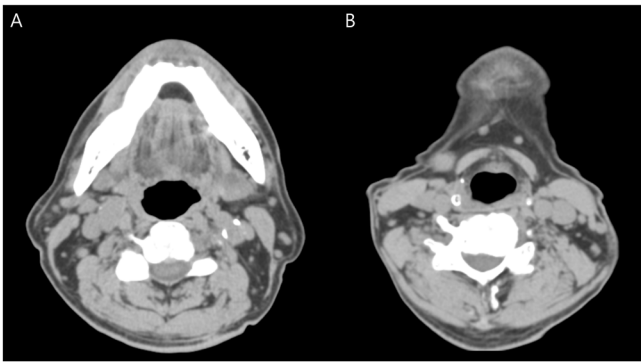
Pre-operative enhanced CT scan. (A) The scan reveals the complexity of distinguishing between a ranula and a lipoma based solely on Hounsfield units, a measure of radiodensity. The Hounsfield units for a ranula typically register around 100, while a lipoma ranges between 65 and 120. This overlap in values makes differentiation challenging. Further complicating the evaluation is the presence of artefacts resulting from the dental crown, which obstructs the clear assessment of soft tissue swelling in the mouth floor. Despite these limitations, the CT scan does not indicate any specific abnormalities in the peripheral bone tissue. (B) Of note, the scan does reveal nodal enlargement in the submandibular and submental regions. This enlargement is interpreted as a reactive lymph node, a common immune response to infection or inflammation. CT, computed tomography.
